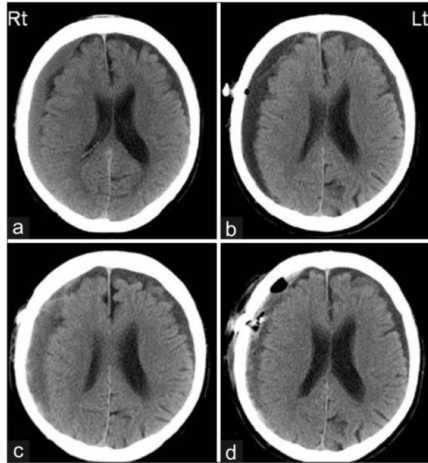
(a) CT scan on admission showing the right CSDH. (b) CT scan after the first irrigation. (c) CT scan 1 month after the second irrigation, showing re-recurrence of right CSDH. (d) CT scan after
